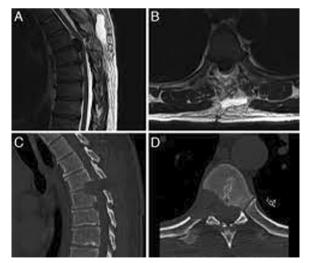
Preoperative T2-weighted MRI of the thoracic spine, sagittal image (A) and axial view (B), exhibiting massive T5–6 central thoracic and smaller T6–7 disk herniations. The patient had previous T6 laminectomies. C and D: Postoperative thoracic spine CT, sagittal image (C) and axial view (D), showing bone decompression at T5–6 and T6–7.37, respectively. [40]
